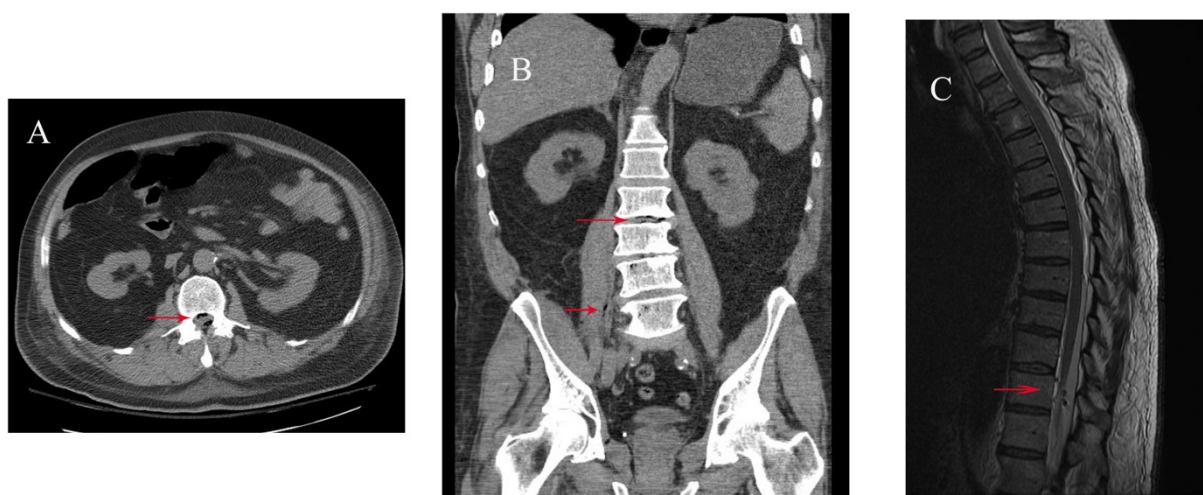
Red arrows indicating air locules on computed tomography (CT) scan of the abdomen and pelvis (A and B) and on Magnetic Resonance Imaging (MRI) (C).
